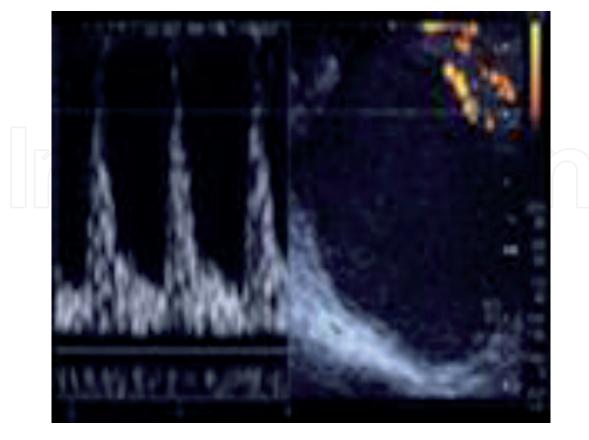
Doppler ultrasound in endometriomas with high PI (pulsatility index).
